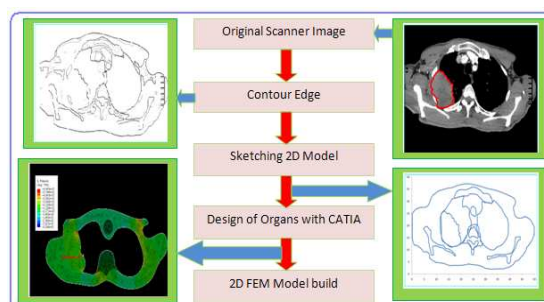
Prospects scheme steps toward the 2D FEM biomedical model from CT images.
